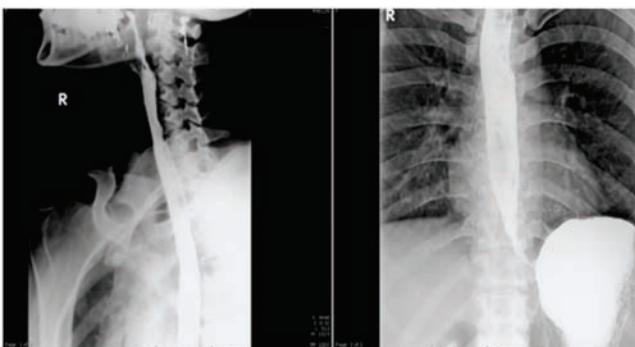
Barium swallow radiograph reveals complete oesophagogram and esophageal constriction at lower end and on fluoroscopy no peristalsis noted.
